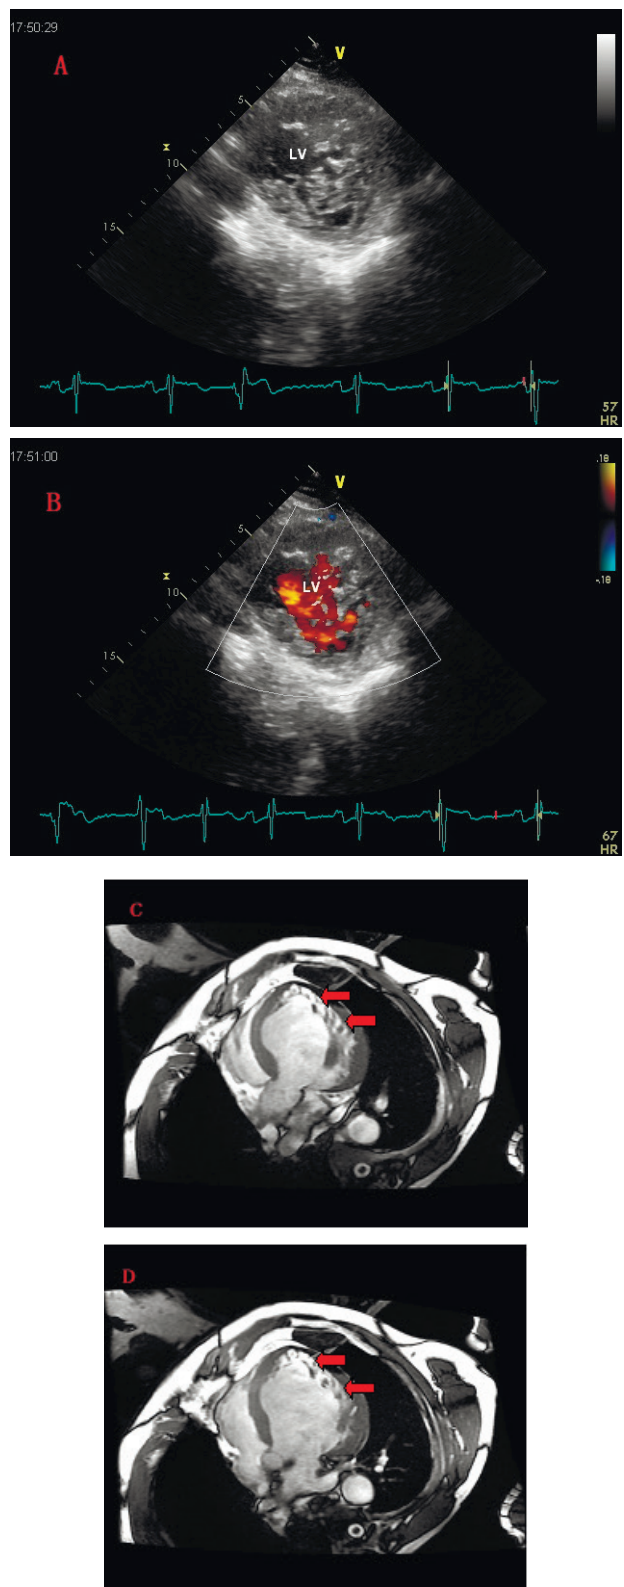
Left parasternal short-axis view at the level of left ventricular apex demonstrates extensive noncompaction (A). Short-axis view in which color doppler ultrasound is used to demonstrate flow within the trabeculae that originates from the ventricle cavity (B). White blood magnetic resonance images acquired in the LV outflow tract view (C) and the four chamber view (D). The LV apical, middle anterior and middle posterior trabeculation/non-compaction are clearly visualised (red arrowed).
